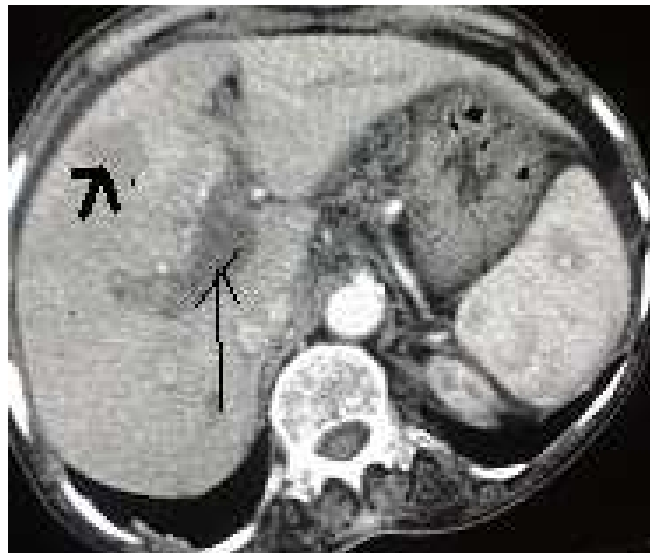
CT Portovenogram with Rt. Portal Vein showing Thrombus inside (arrow). THAD (Bold Arrow)
